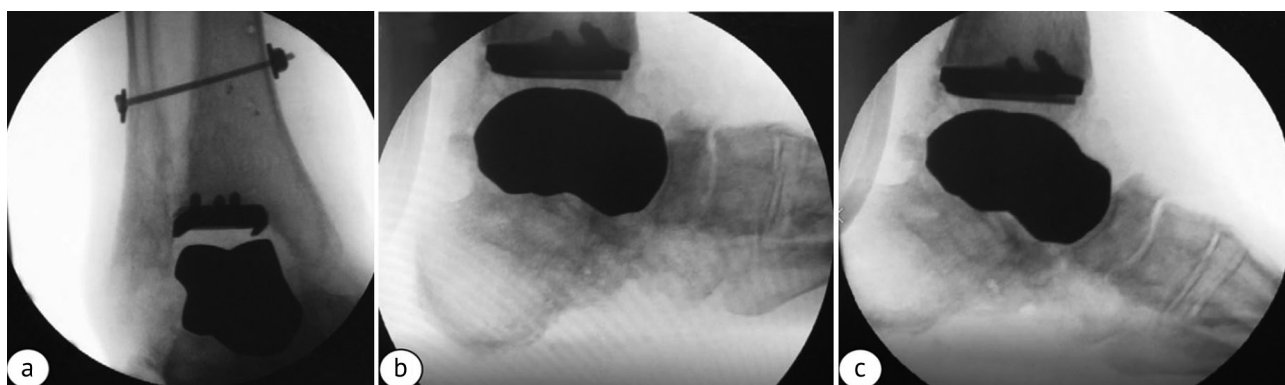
Follow-up radiographs of the ankle joint 20 months after the operation: a AP radiograph, there is a good alignment of the metal implants, preservation of the contours of the ankle joint; b, c functional radiographs in the lateral view with dorsiflexion and plantar flexion of the foot: good position of the endoprosthesis components, total range of motion 28°
